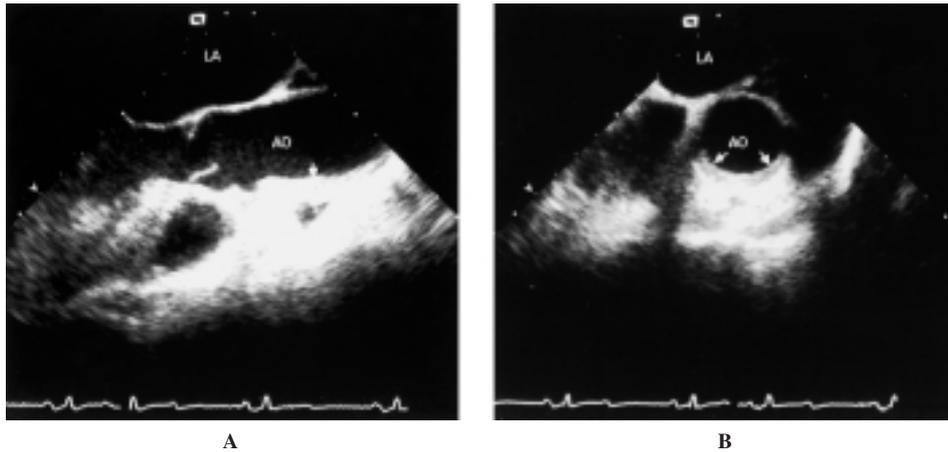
Transesophageal echocardiographic study 24 hours following the coronary intervention procedure. A: long axis of the ascending aorta (AO); B: short axis of the ascending AO. LA = left atrium.
